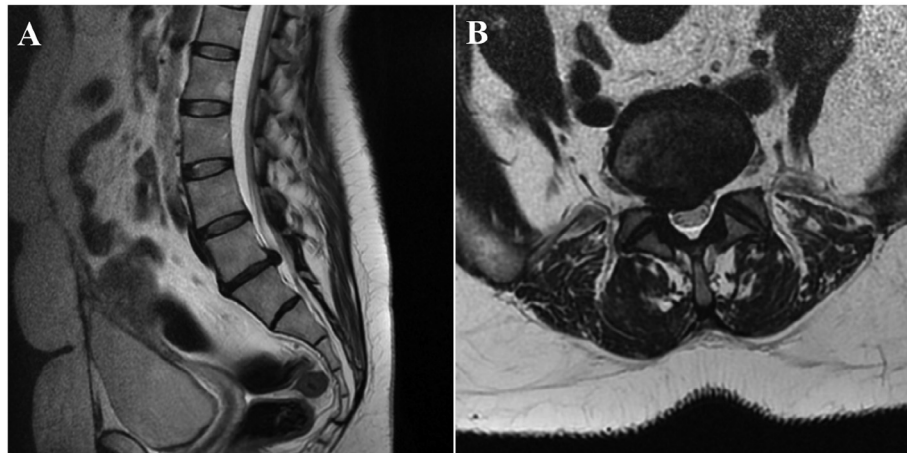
Preoperative sagittal (A) and axial (B) T2-weighted MRI sequences showing a median-paramedian right L5-S1 disc herniation.
